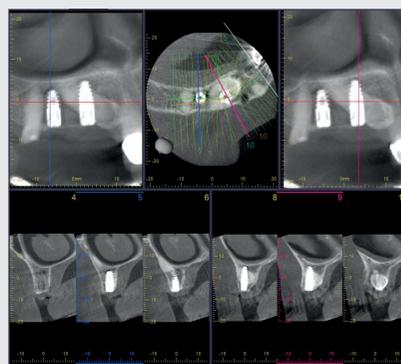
Control CBCT small FOV
